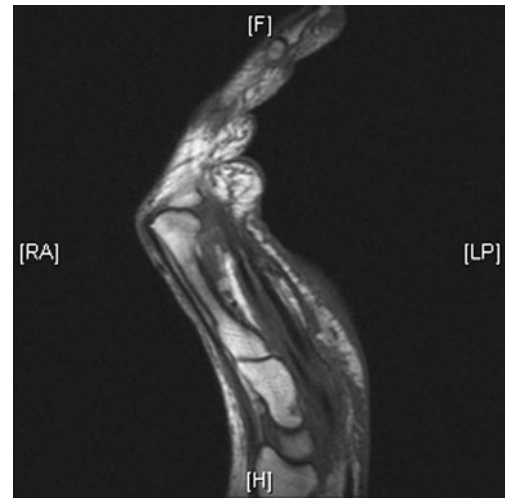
Increased T2 prolongation confined to the deep fascial plane in the palm and the subcutaneous tissue along the dorsal wrist extending into the dorsal fingers without any abnormal signal noted within the muscle. These areas of T2 prolongation enhanced on the fat suppressed T1 sequence and are consistent with fasciitis. Radiography of the left hand was not done because the patient reported discomfort
